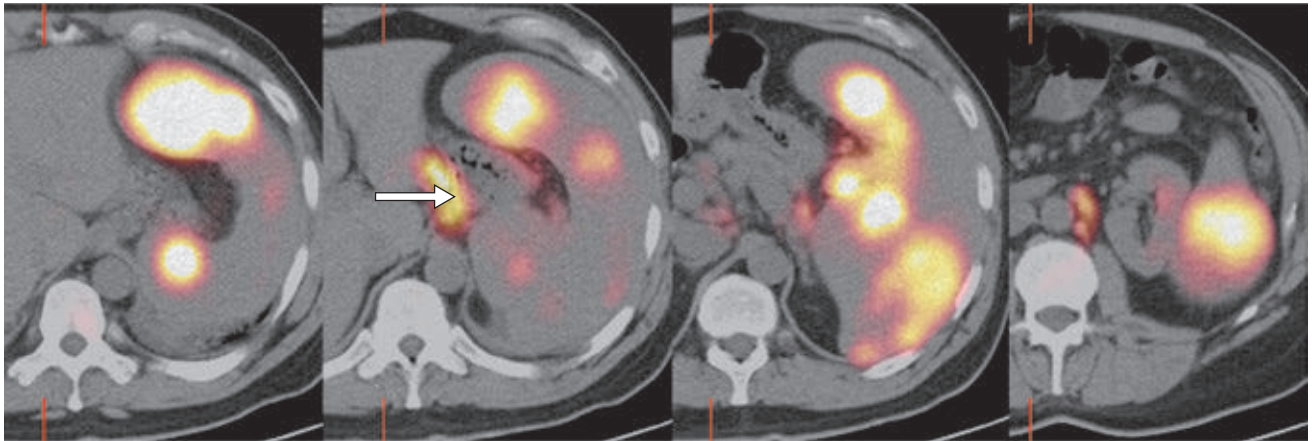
Combined PET scan and CT. Color represents PET scan results indicating distribution of ^{18}F -FDG metabolism in spleen (large organ on right of images) of a patient with lymphoma (cancer of lymphocytes). The PET scan has detected the spread of the cancer to adjacent lymph nodes (arrow in second image).
